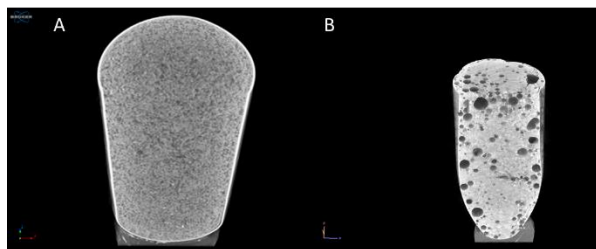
Micro-CT of samples (A: ultra turrax type, B: ultrasonic type).
